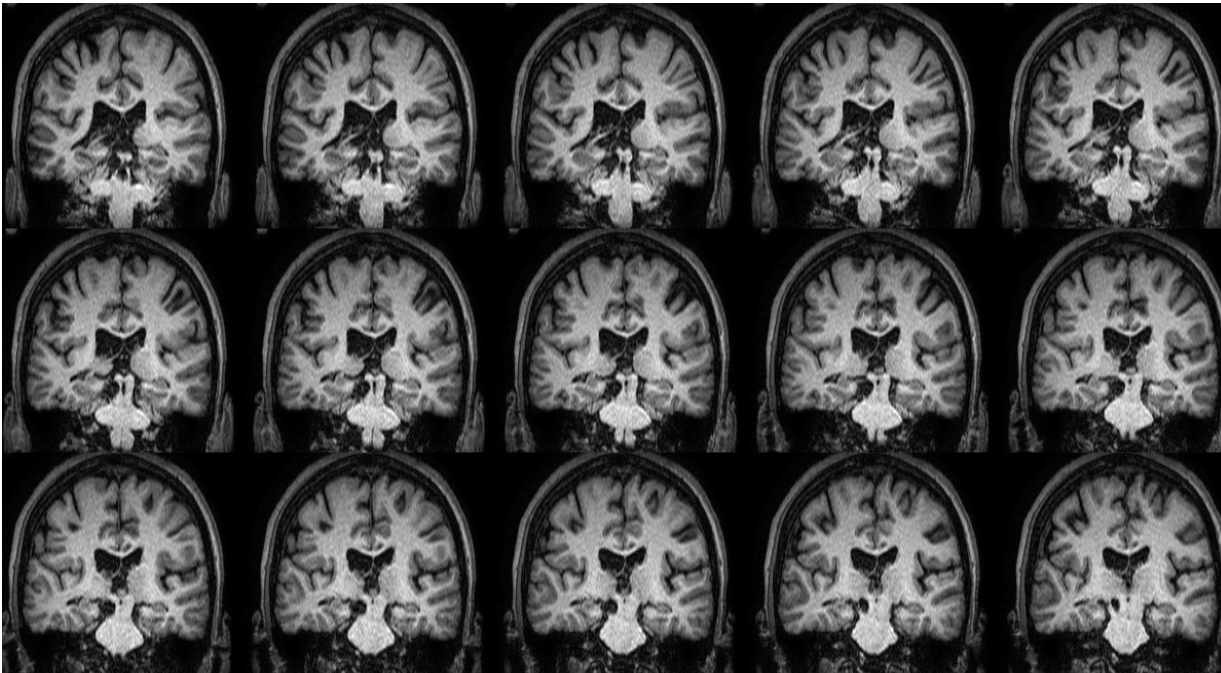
A series of MRI T1 coronal sections of LM are shown from posterior (top left) to anterior (bottom right). These scan display the extent of the IC lesion.
